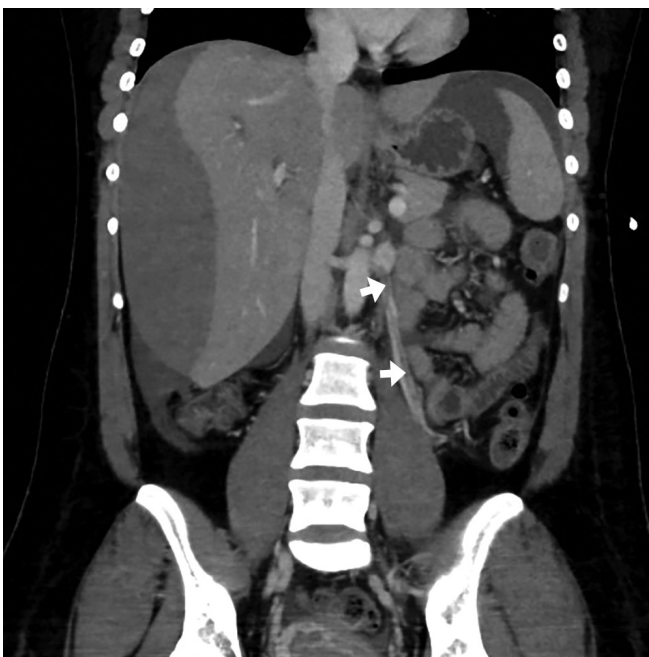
Coronal portal venous phase computed tomography scan of a 39-year-old woman on postpartum day 2 showing gonadal vein thrombosis (arrows) and stable appearance of hepatic hematoma.
